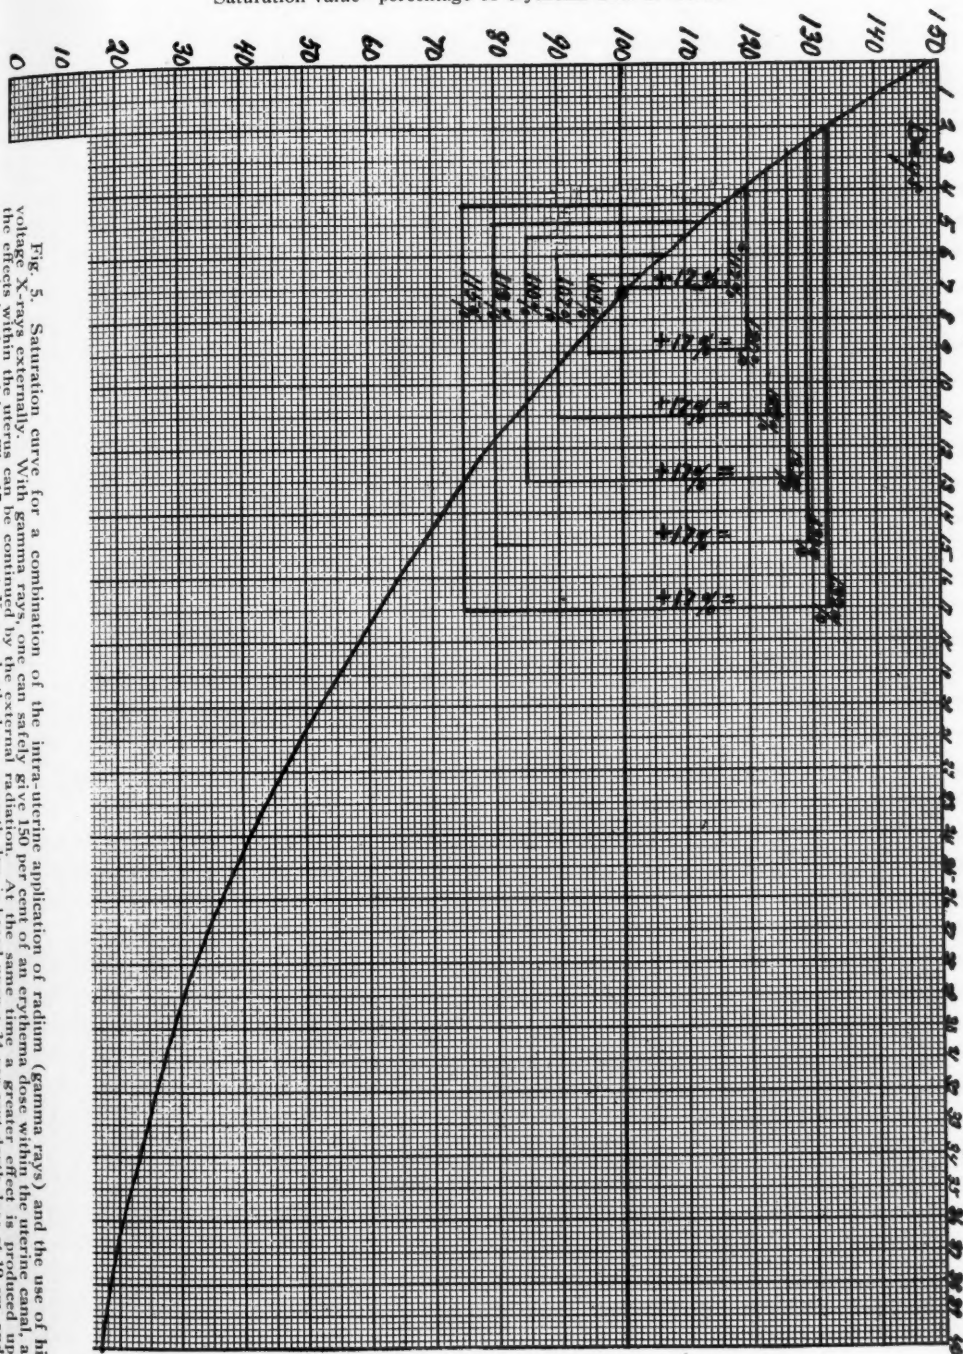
Saturation curve for a combination of the intra-uterine application of radium (gamma rays) and the use of high voltage X-rays externally. With gamma rays, one can safely give 150 per cent of an erythema dose within the uterine canal, and the effects within the uterus can be continued by the external radiation. At the same time a greater effect is produced upon the external surface of the uterus. The curve is based upon a 150 per cent dose of an erythema dose at 19 cm. and a 50 per cent surface dose on one of three points of curve, on alternate days, or half this quantity daily.
